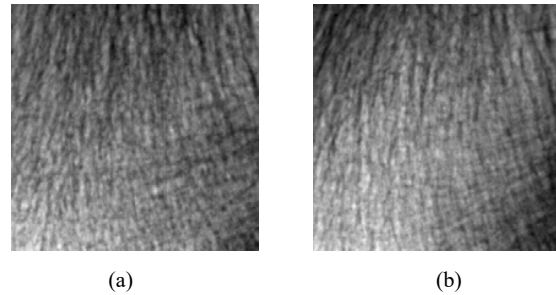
Trabecular bone radiographs image, (a) control patient (b) OP
